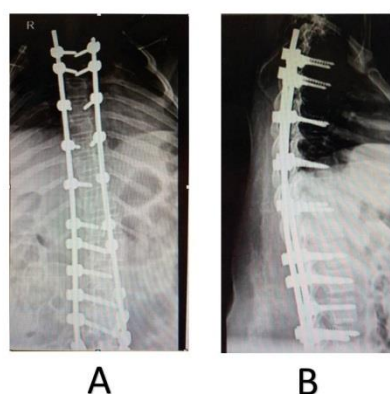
Post-operative x-rays; (A) anteroposterior (AP) view, (B) lateral view
